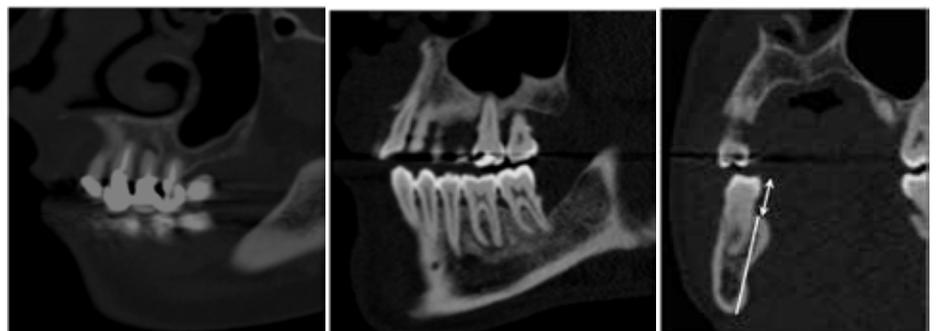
A typical CAP lesion of a tooth (14) in a semi-coronal reconstruction of a CT. The tooth shows an endodontic filling (a), a CAP lesion of a tooth (46) in a semi-sagittal reconstruction of a CT (b), and a semicoronal reconstruction in the region 46 (c), showing the methods of measurement of the distance between the crown and the alveolar ridge (double arrow) and of measurement of the height of the bone (white line).
